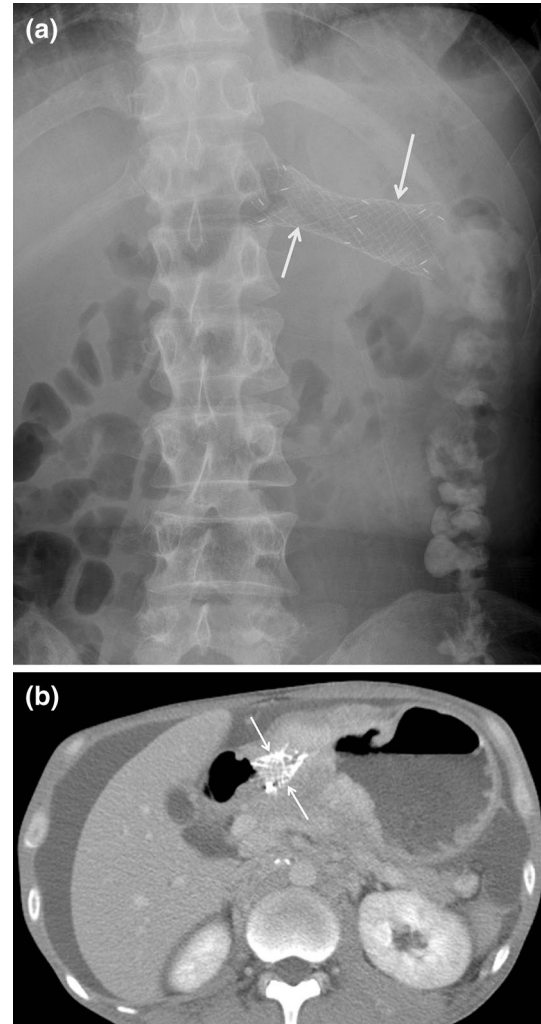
Fracture of a pyloric stent in a 44-year-old male with stomach cancer who had a history of vomiting the fragmented stent. a Abdominal radiograph shows a pyloric stent (*arrows*) in the upper abdomen. b A follow-up CT image taken 70 days later shows a remaining stent fragment (*arrows*) in the gastric pylorus. Subsequently, a new pyloric stent placement was performed (not shown)
